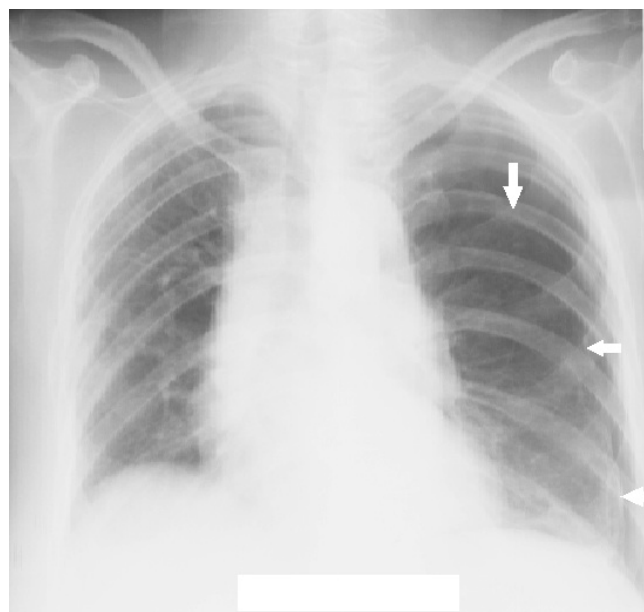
PA X-ray demonstrated a pneumothorax line in her left hemithorax (see arrows)
